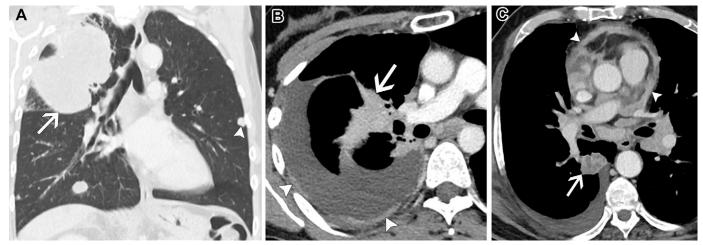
M1a metastatic disease in three patients. (A) Coronal contrast-enhanced chest CT image (lung window) in a 59-year-old woman with NSCLC shows a right-upper-lobe primary mass (arrow), with an additional tumor nodule in the left lower lobe (arrowhead); another metastasis is seen in the right lower lobe. (B) Axial contrast-enhanced chest CT image (soft-tissue window) in a 63-year-old man with NSCLC shows a right-upper-lobe primary mass (arrow) involving the right hilum, associated with right pleural metastases (arrowheads) causing a pleural effusion. (C) Axial contrast-enhanced chest CT image (soft-tissue window) in a 75-year-old man with NSCLC shows a right-lower-lobe mass (arrow) associated with pericardial metastasis encasing the pericardium (arrowheads).
